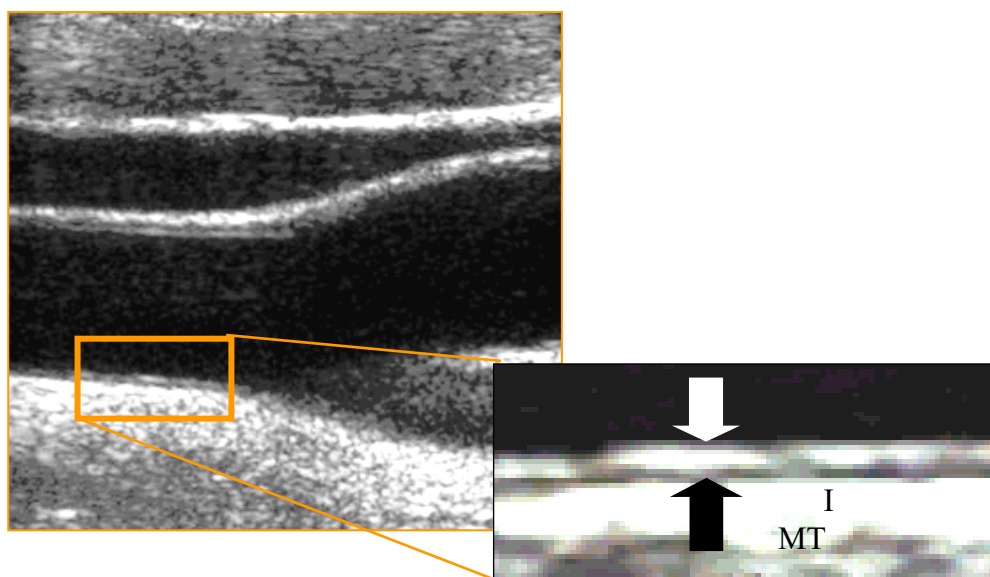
Carotid IMT. The layers between the black (media-adventitia interface) and the white (lumen-intima interface) arrow represent the intima-media layers in the ultrasound image.
